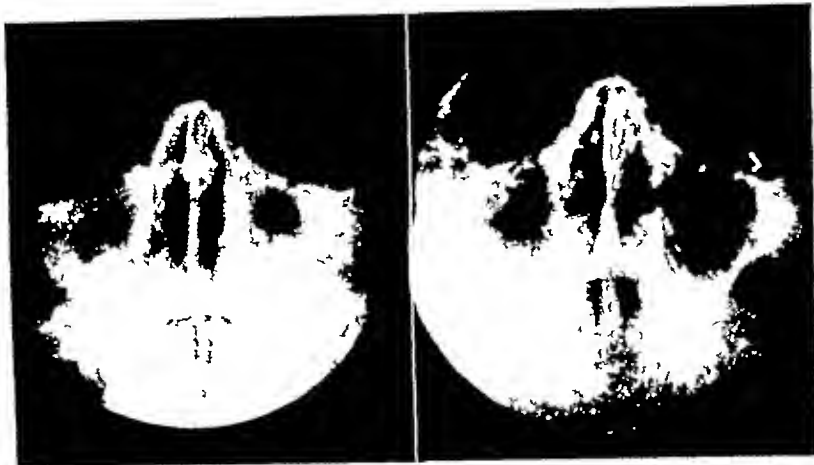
Case 1 Radiograph of the antra at the time of the first treatment. Symptoms date back four years.
